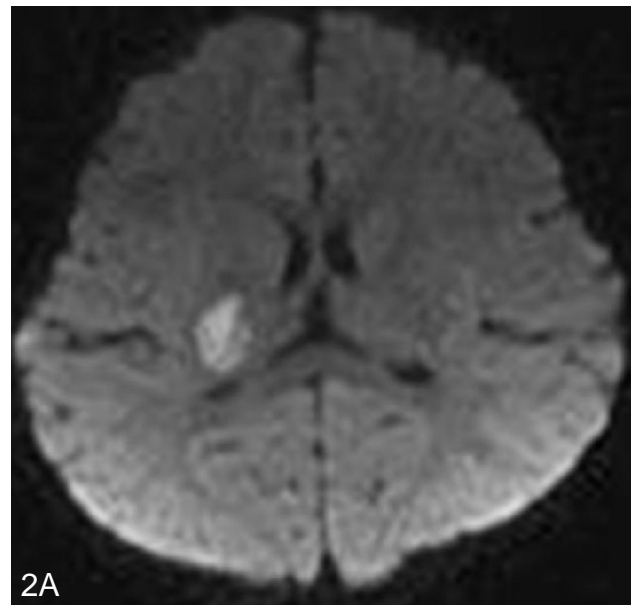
MRI: DWI (A) and ADC (B) show restricted diffusion with low ADC values suggestive of acute nonhemorrhagic infarct in dorsal portion in right lentiform nucleus and adjoining posterior limb of internal capsule.
